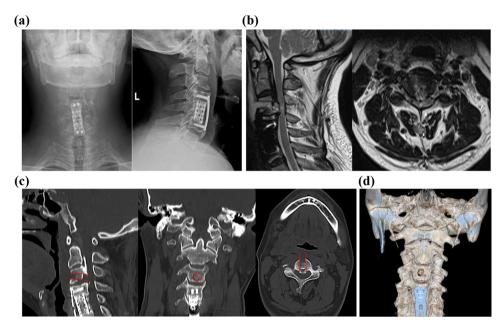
Radiological images at 2 days after the second operation. (a) Anteroposterior and lateral X-ray image; (b) Sagittal and axial magnetic resonance imaging images; (c) Sagittal, coronal and axial computed tomography (CT) image (red mark: re-implanted bone plug); (d) 3-dimensional reconstruction of the cervical spine
